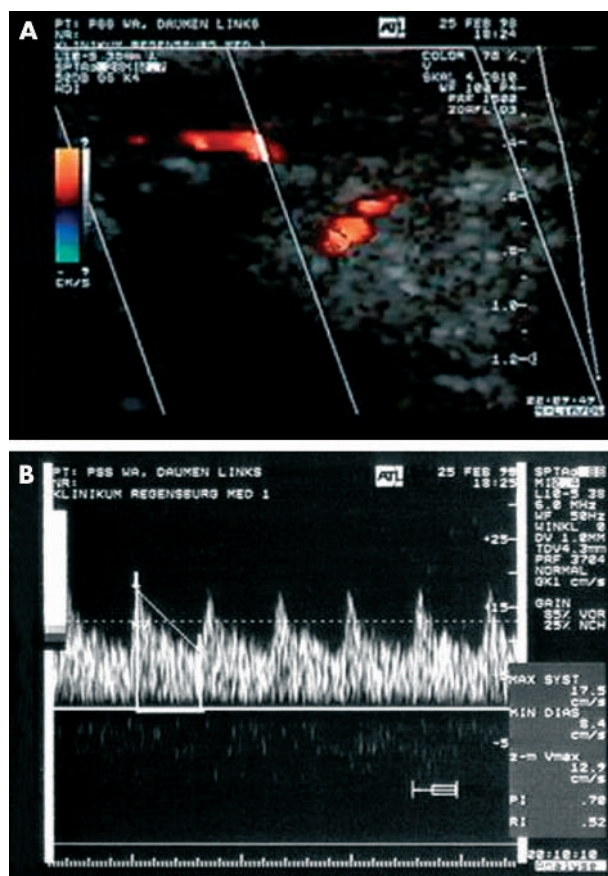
Picture of a colour Doppler ultrasound (A) and the associated spectral waveform (B) of the distal artery of the left thumb (patient with diffuse disease).
